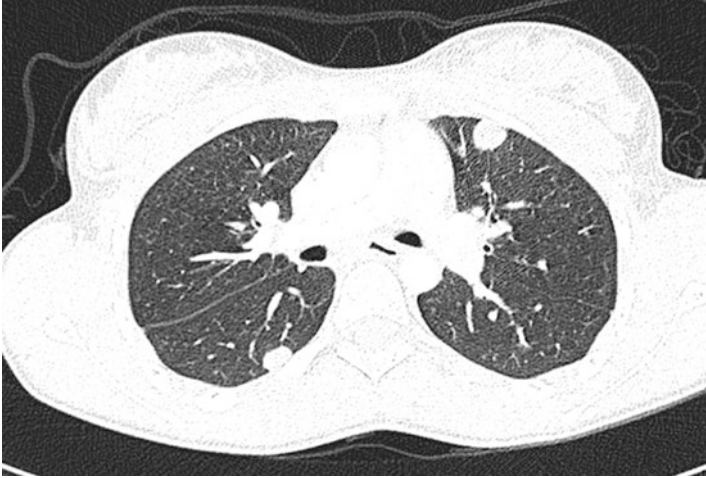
CT chest: (not required)
